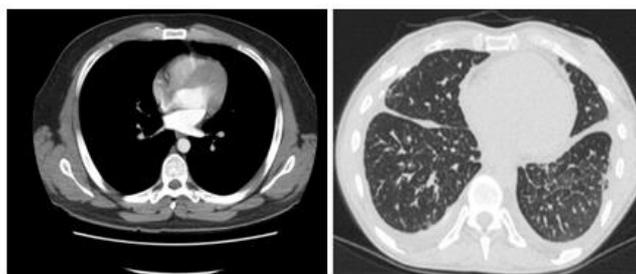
Normal CT Chest (left) and Abnormal CT chest (right)[16]
